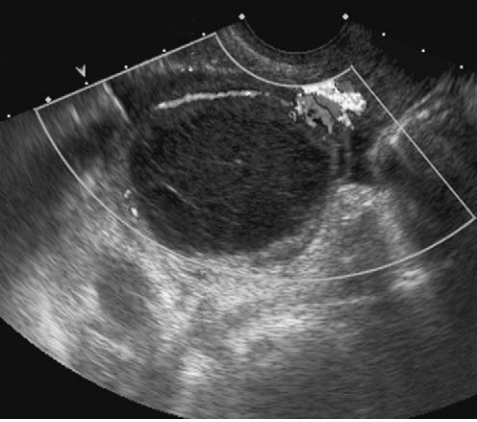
Hemorrhagic cyst. Transvaginal ultrasound of a hemorrhagic cyst shows the characteristic mesh of fine linear echoes referred to as a “lacy” or “fish net” appearance. Color Doppler shows absence of blood flow in the fine septations.
